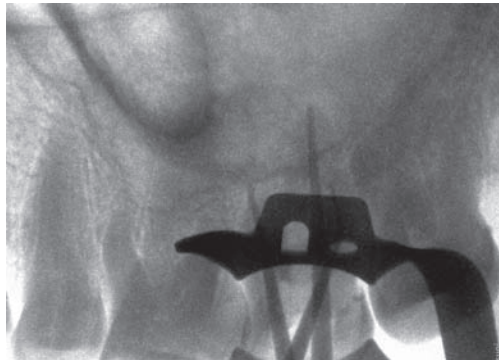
Mastercone as determined by radiograph
